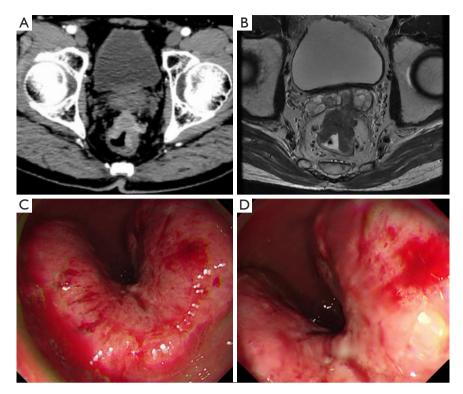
Imaging examination of the patient's lesion site. (A) CT scan and (B) MRI showed the thickened anterior wall and nodules of the middle rectum, the lumen of which was narrowed. (C,D) Colonoscopy showed the surface of the tumor was uneven and the mucous membranes was hyperemia and edema. CT, computed tomography; MRI, magnetic resonance imaging.
